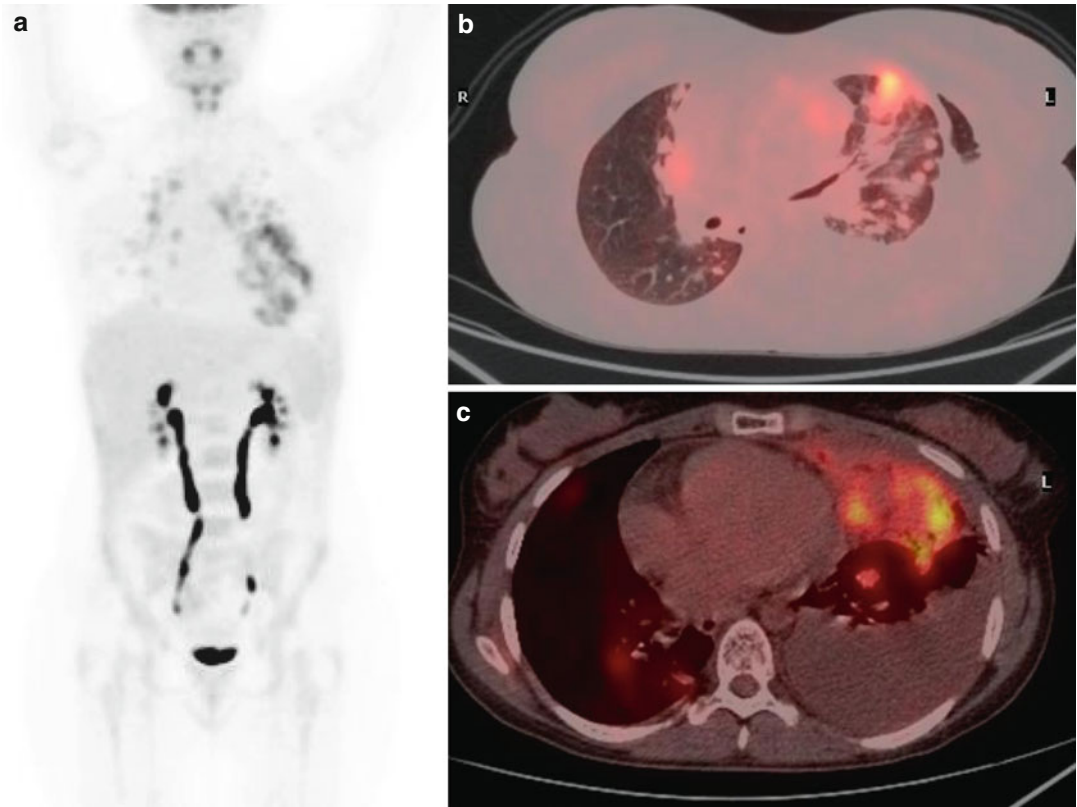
(a–c) PET/CT 3 months after the completion of RT revealed new multiple hypermetabolic lung nodules bilaterally (SUVmax 4) (a and b) and a left paracardial-epiphrenic mass (SUVmax 7) (c), while the uptake at the residual original mediastinal mass was milder (SUVmax 4) (a)
